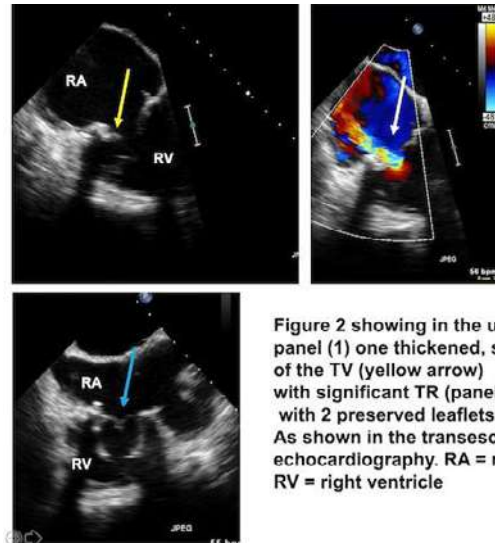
showing in the upper left panel (1) one thickened, shrunken leaflet of the TV (yellow arrow) with significant TR (panel B, white arrow) with 2 preserved leaflets (C, green arrow) As shown in the transesophageal echocardiography. RA = right atrium; RV = right ventricle
